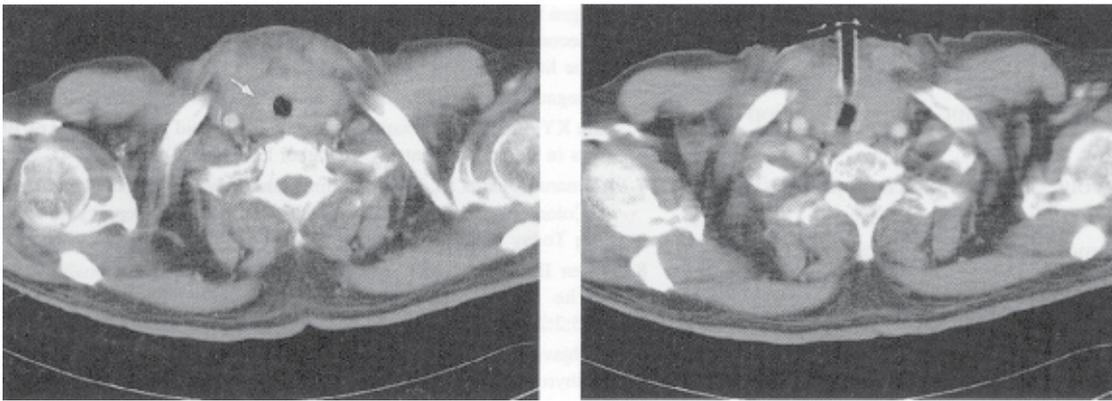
A preoperative CT scan image of a large thyroid mass (indicated by arrow) surrounding the trachea resulting in airway compression necessitating tracheostomy. Fig. 1b. A CT scan image after tracheostomy has been performed.
